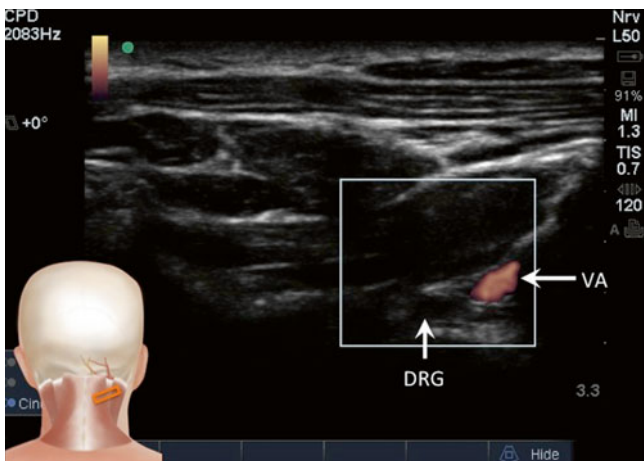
Doppler scan of Fig. 12.7 showing the vertebral artery (*VA*) and the dorsal root ganglion (*DRG*) (Reproduced with permission from Philip Peng Educational Series)
